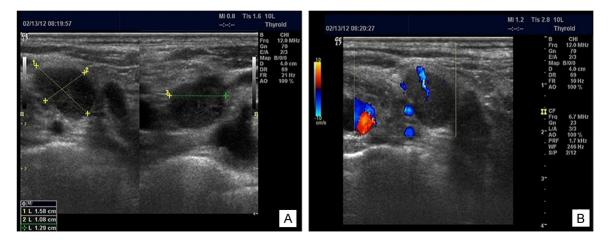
Ultrasound image of lymph nodes in ALNM group. A. Ultrasound gray-scale image: The ultrasound shows multiple hypoechoic nodules, unclear boundary of cortex and medulla and enlargement of lymph nodes (as large as about $1.6 \times 1.3 \times 1.1$ cm, with an aspect ratio of 1.3). B. Blood flow signals can be seen in CDFI.
